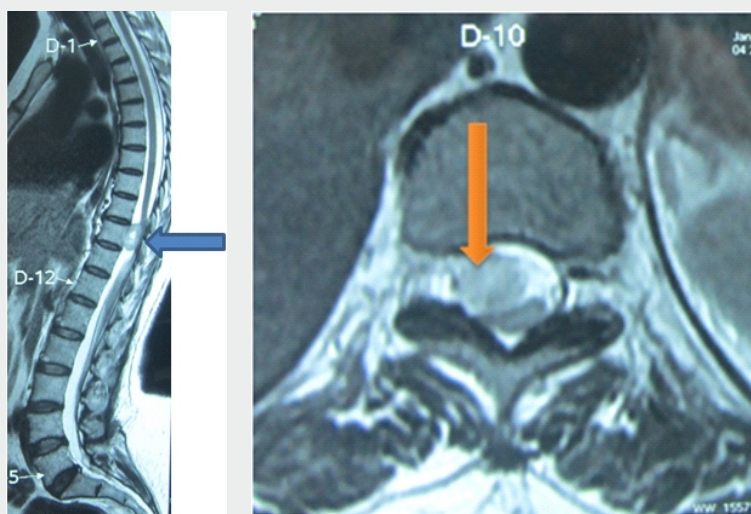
MRI sections of Case 1, showing a large ventral intradural mass at D9-10 level severely compressing the spinal cord at that level.
